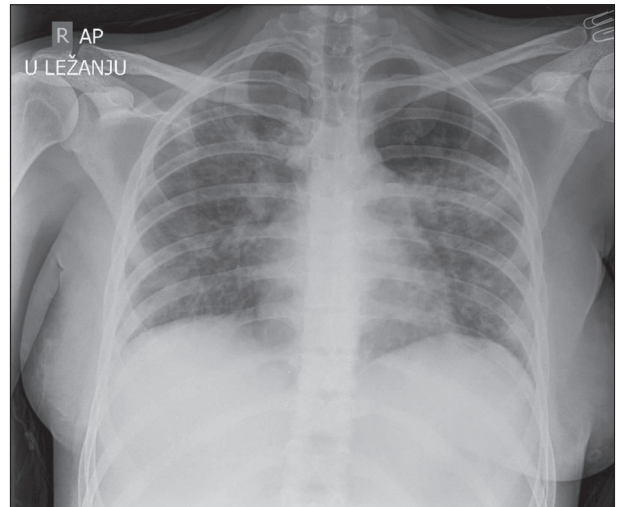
X-ray of the patient's heart and lungs 14 days after the administration of two doses of tocilizumab; significant regression of inflammatory changes in the lung parenchyma on both sides
